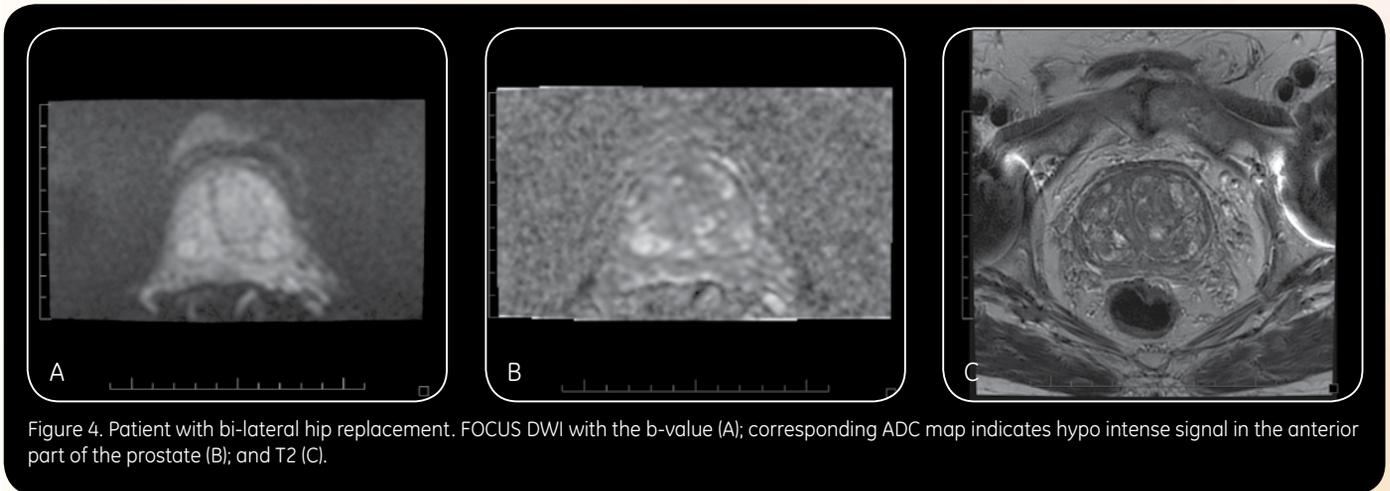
Patient with bi-lateral hip replacement. FOCUS DWI with the b-value (A); corresponding ADC map indicates hypo intense signal in the anterior part of the prostate (B); and T2 (C).
